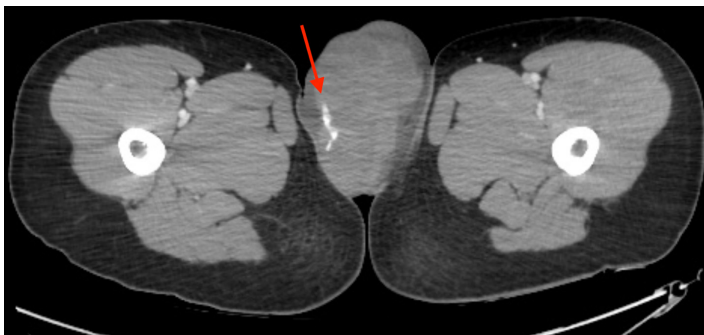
Computed tomography with angiography of the pelvis in axial view demonstrating arterial extravasation (red arrow) with surrounding hematoma formation extending into left vulva.
